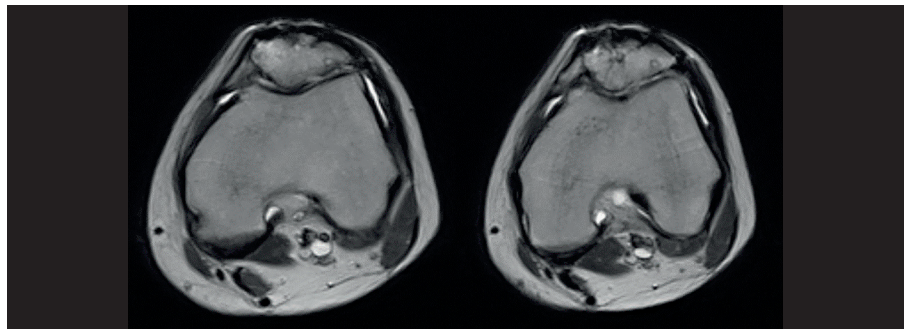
The MRI at 6 months shows an improvement in the femur-patella surfaces, improvement of the cancellous signal of the patella due to partial regression of the osteonecrosis areas, and the presence of a thin but even chondral signal.
